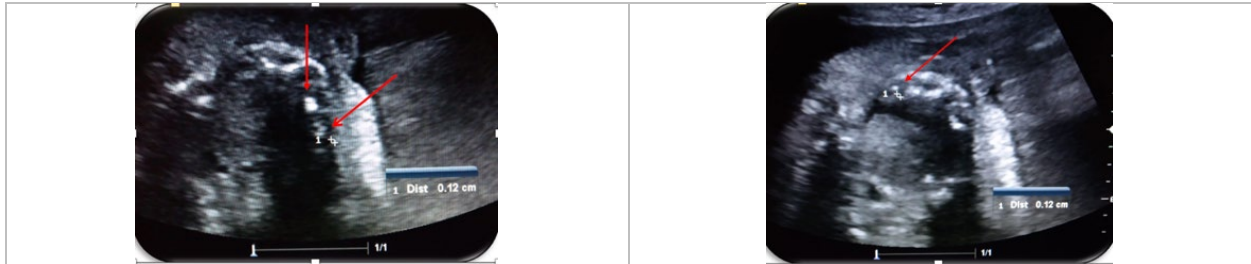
Sagittal ultrasound section of the fetal craniofacial region highlighting the alveolar dental buds.
